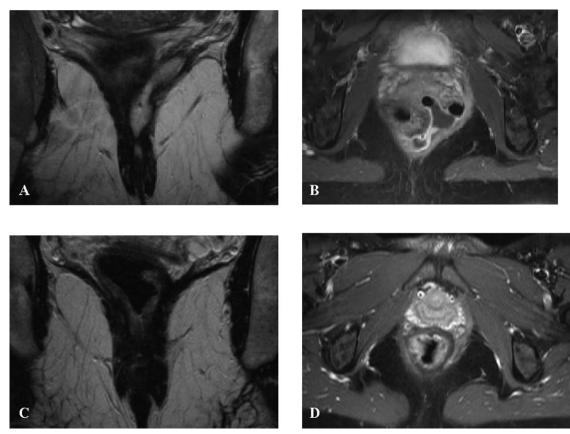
Pelvic MRI scan of a 41-year-woman with a pure anoperineal CD. On coronal T2 MRI at baseline (A), the suprasphincteric fistula track extended to a supralevator collection was hyperintense and enhanced on axial T1 after gadolinium injection showing a horseshoe extension and a marked thickening of the rectal wall (B). At week 50, after a second surgical reconstructive surgery associating flap with fibrin glue application, the patient had a complete clinical response with disappearance of hyperintensity on T2 (C), and of enhancement after gadolinium injection on T1 associated with persisting mild thickening rectal wall (D).
